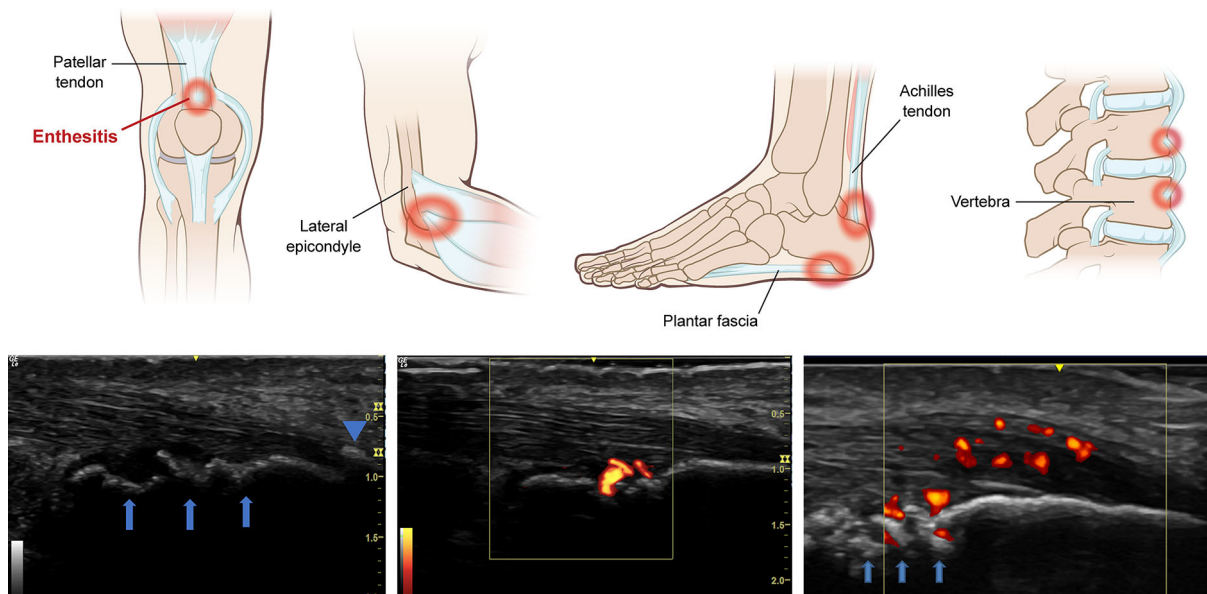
Imaging of entheses by ultrasound. *Top*: enthesal structures. *Bottom left and center*: ultrasound (*left*) and ultrasound with Doppler images (*center*) of the right Achilles tendon of a patient with PsA experiencing no tenderness on clinical examination. Visualized changes include erosion/cortical irregularities (*arrows*) and distal
